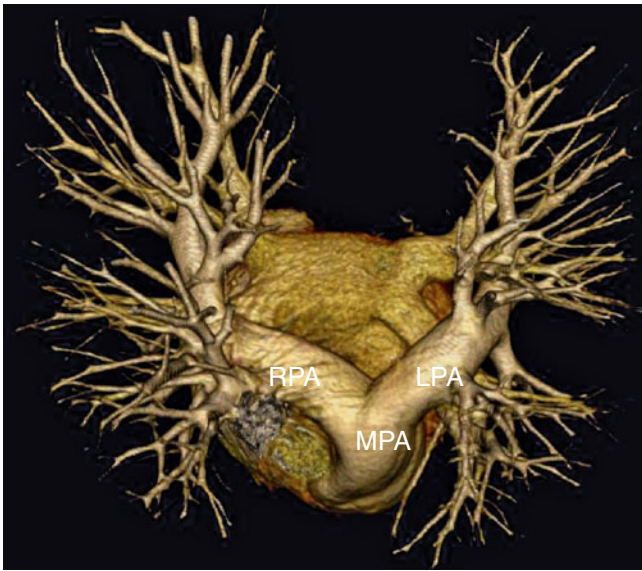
A volume-rendered posterior-oriented 3-D CT image identifying the main pulmonary artery by its associated branches. *MPA* main pulmonary artery, *RPA* right pulmonary artery, *LPA* left pulmonary artery. One or more pulmonary arteries arising from the main pulmonary artery is the signature of the pulmonary artery
